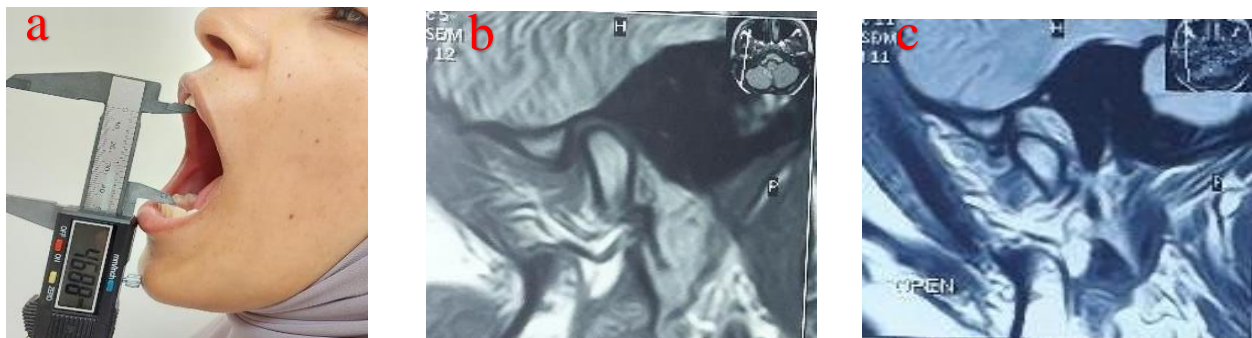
Postoperative photographs showing a. Clinical photograph showing improved maximum voluntary mouth opening b. MRI in the closed-mouth position demonstrating proper disc position c. MRI in the open-mouth position showing disc recapture and improvement in osteoarthritic changes of the condylar head.
